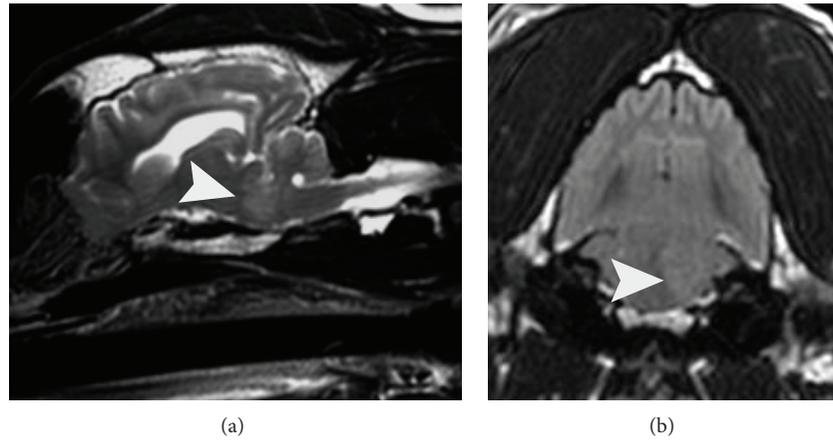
(a) T2-weighted sagittal and (b) FLAIR transverse pulse sequences of the brain, at the level of the pons. There is a broadbased ill-defined homogeneous hyperintense lesion (arrowhead) along the sphenoid bone, encompassing approximately fifty percent of the left side of the pons and extending dorsal to the fourth ventricle, which appears slightly displaced to the right.
